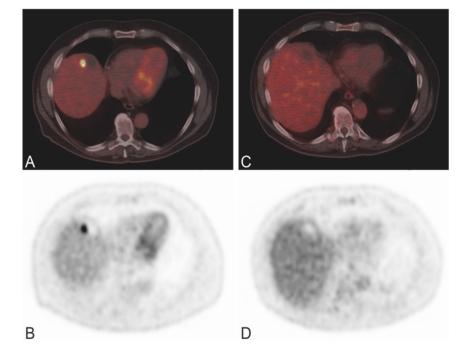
Response monitoring liver metastasis. Images of PET/CT (A, C) and PET (B, D) before (A, B) and after six cycles of therapy (C, D).
